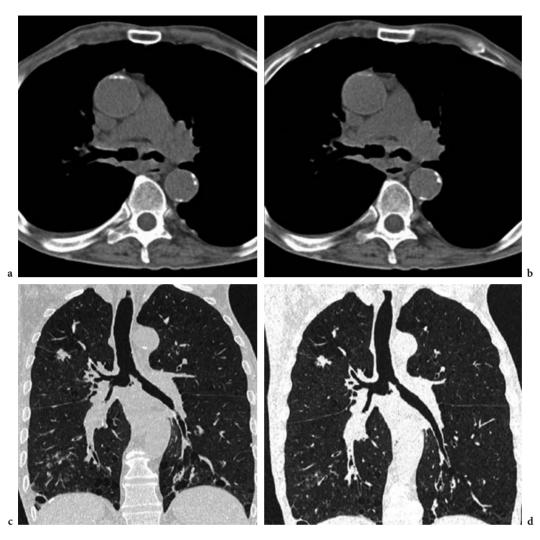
A 67-year-old man 1.83 m tall and weighing 69 kg ($BMI = 20 \text{ kg/m}^2$) is referred for CT for cough and fever. MDCT chest acquisitions with parameters displayed at the bottom of the figure are obtained using an AEC device and a 32×0.6 mm beam collimation, at 120 kVp. A nodule is seen in the right upper lobe, centrilobular ill-defined nodules are seen in the right lower lobe and a tumor infiltrating the carina is seen in the mediastinal window. a, c Obtained with a reference quality mAs set at 90 mAs; b, d obtained with a reference quality mAs set at 60 mAs (effective). Delineation of mediastinal structures is not modified by the 33% dose reduction applied between a and b, and c and d
